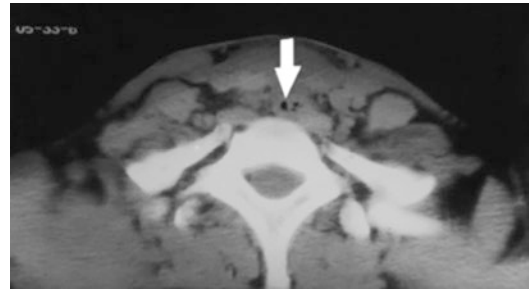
CT scan at the level of the hyoid bone demonstrating subcutaneous emphysema. The airway can only be identified by the presence of an endotracheal tube
